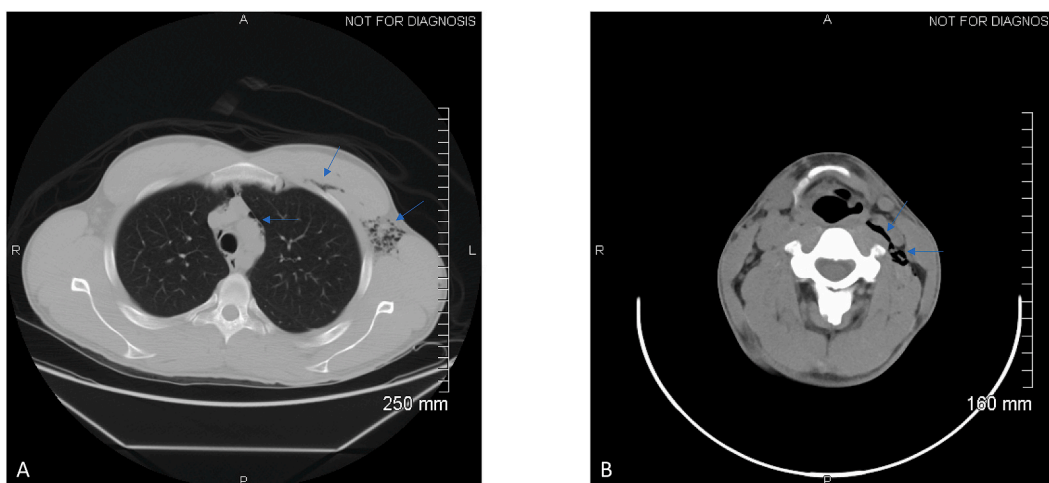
3A CT of the chest without IV contrast showed gas and soft tissues of the left neck and chest consistent with patient's known pneumomediastinum. 3B CT of the neck without IV contrast showed gas and soft tissues of the left neck.
